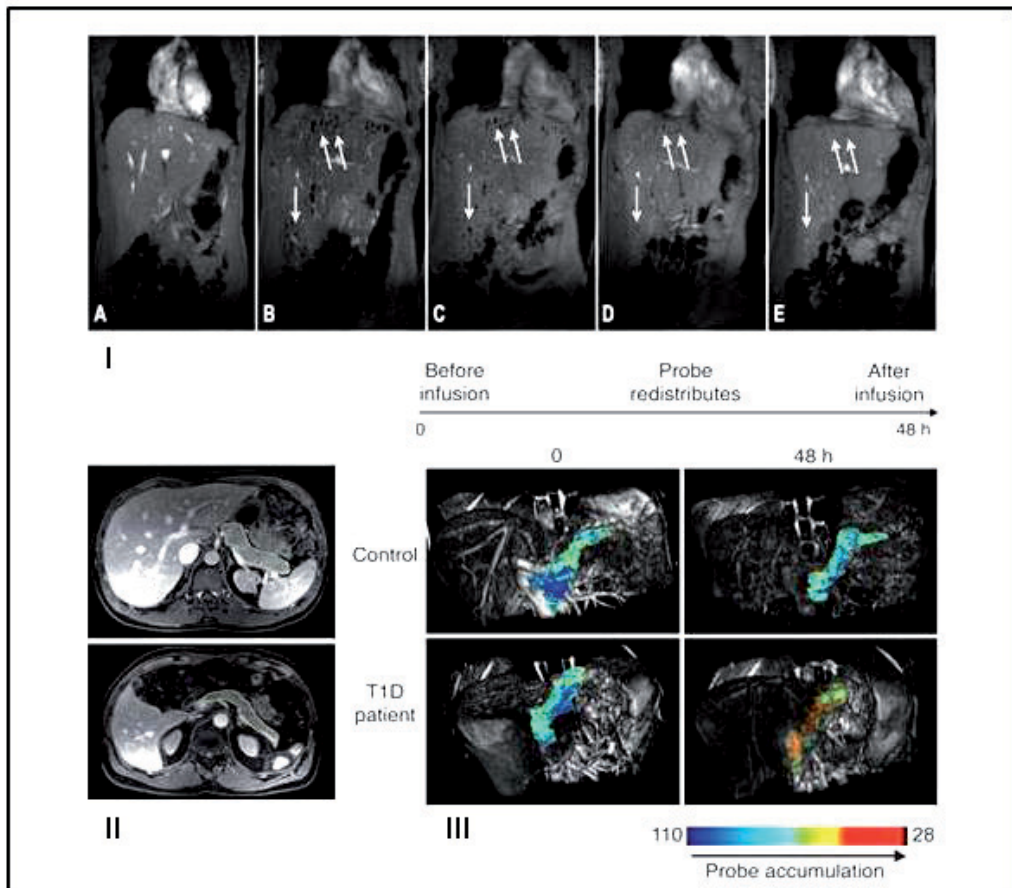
I. Magnetic resonance imaging in a T1D patient on the day before transplantation (A), 1 day (B), 1 week (C), 4 weeks (D), and 24 weeks after transplantation (E). Typical areas of signal loss attributed to the detected islets are indicated by arrows (Saudek et al., 2010).
